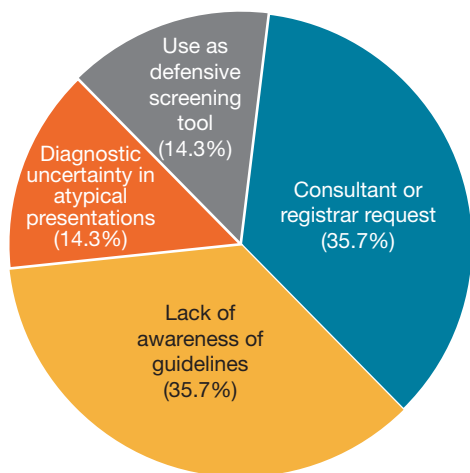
Reasons for inappropriate abdominal X-rays request based on a qualitative survey distributed among junior doctors in acute medical initial admissions unit.
